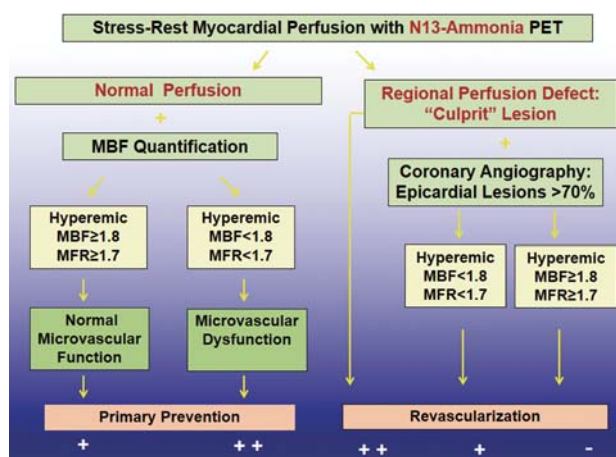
Algorithm for the Integration of ^{13}N -ammonia PET/CT Perfusion Images and MBFs in Multivessel CAD
